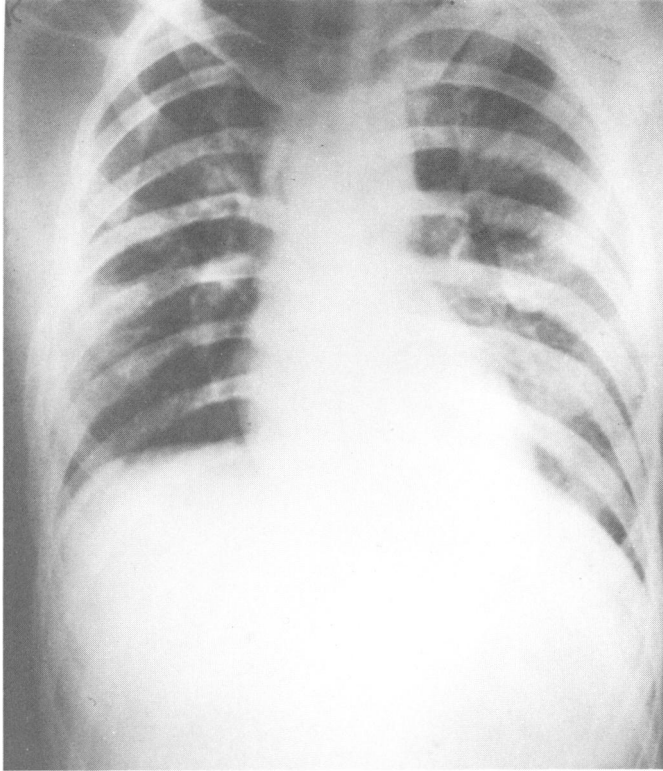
Postoperative chest x-ray showing complete resolution of the right chylous effusion.
